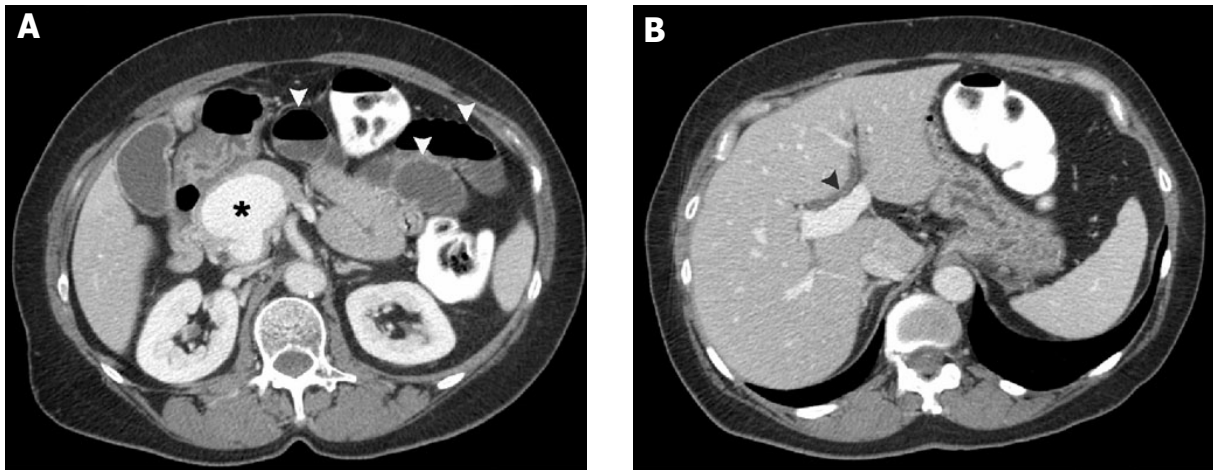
X-year-old man/woman with symptom lo Figure 1. 61-year-old woman with extrahepatic portal vein aneurysm. Contrast enhanced CT image (A) demonstrates small bowel obstruction, evidenced by dilated small intestinal loops with air-fluid levels (arrowheads). 5 cm diameter extrahepatic portal vein aneurysm (asterisk) located at superior mesenteric vein and splenic vein confluence. (B) Intrahepatic portal vein shows normal caliber. Mild dilation of the intrahepatic biliary system is evident (arrowhead).
